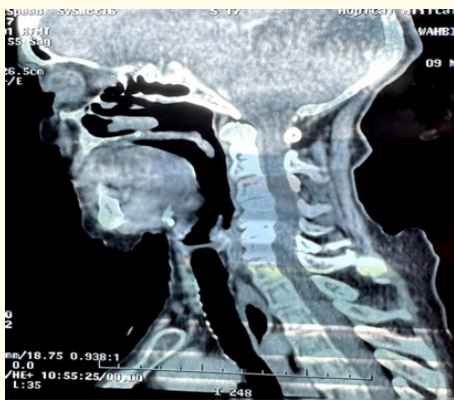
Cervical CT scan showed anterior osteophytes.
